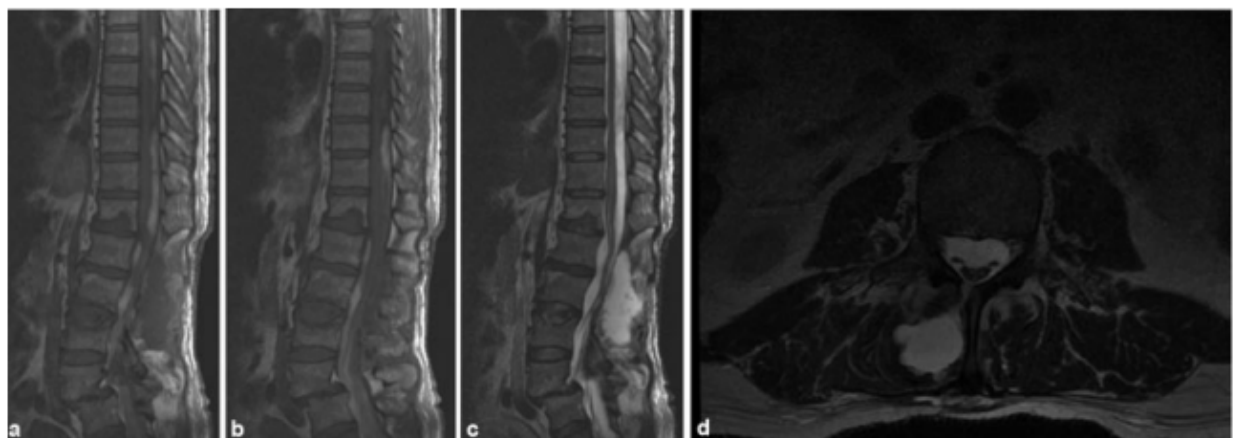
(a–d) Sagittal magnetic resonance imaging performed 12 days after surgery documented a reduction of spinal subarachnoid hemorrhage, visible also on the axial image (d).
